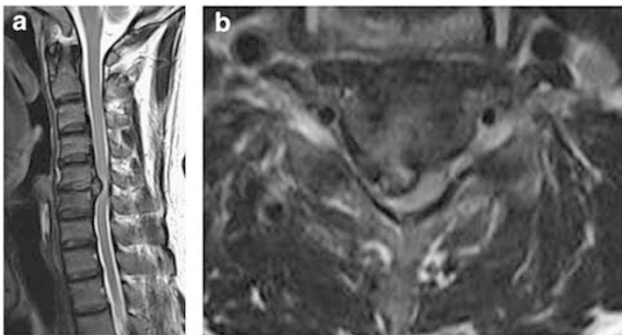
Sagittal T2- (a) and axial T1-weighted (b) MR images in Case 3 demonstrating a large herniated disc causing significant compression of the right side of the spinal cord at the C5–C6 level
